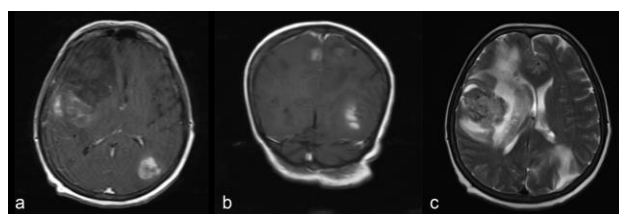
MRI images of the metastatic lesions are seen in (a) contrast-enhanced T1-weighted axial, and (b) coronal sequences. The extent of edema and midline shift is best visualized in (c) T2-weighted axial sequence.
